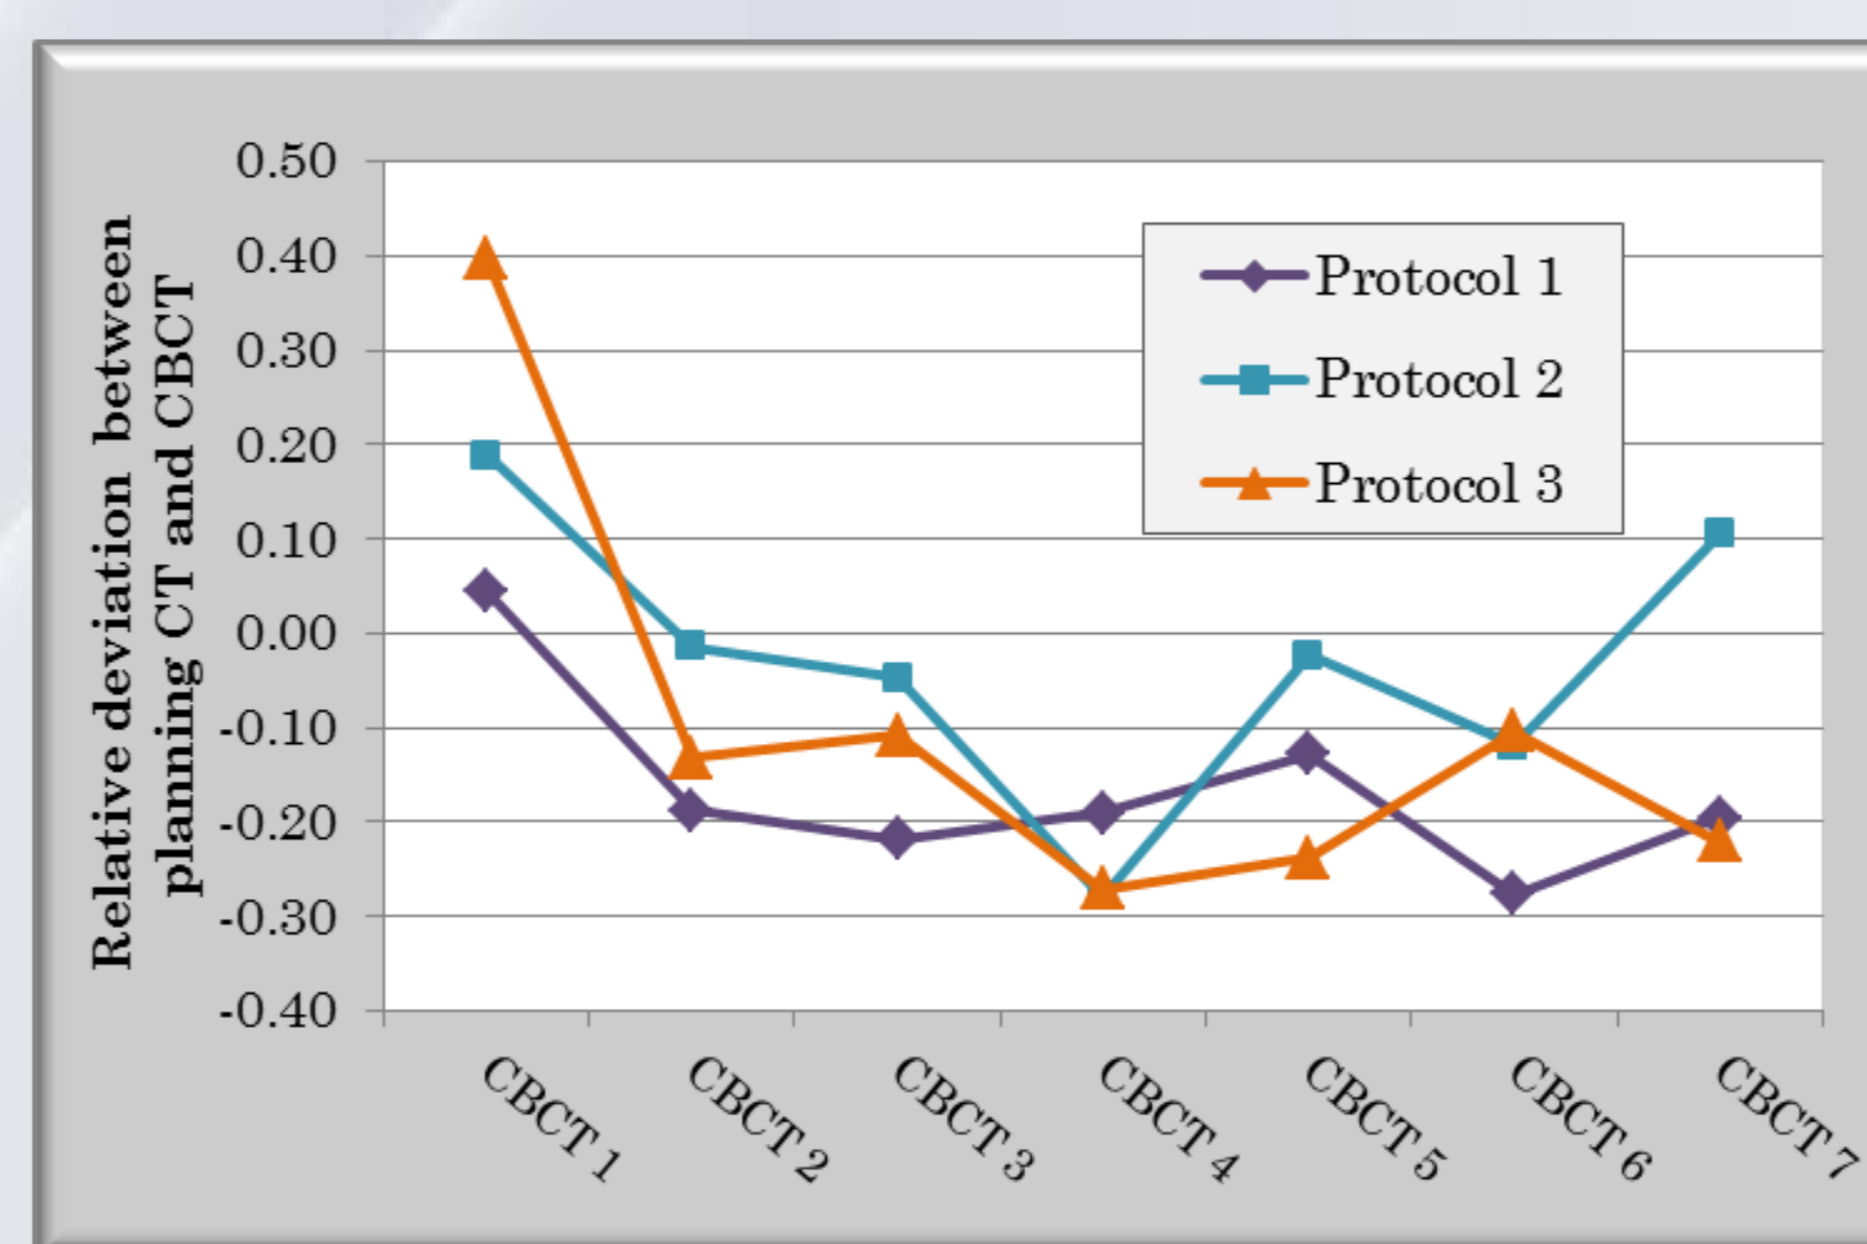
Relative deviation of bladder volume between planning CT and weekly acquired CBCT scans.
